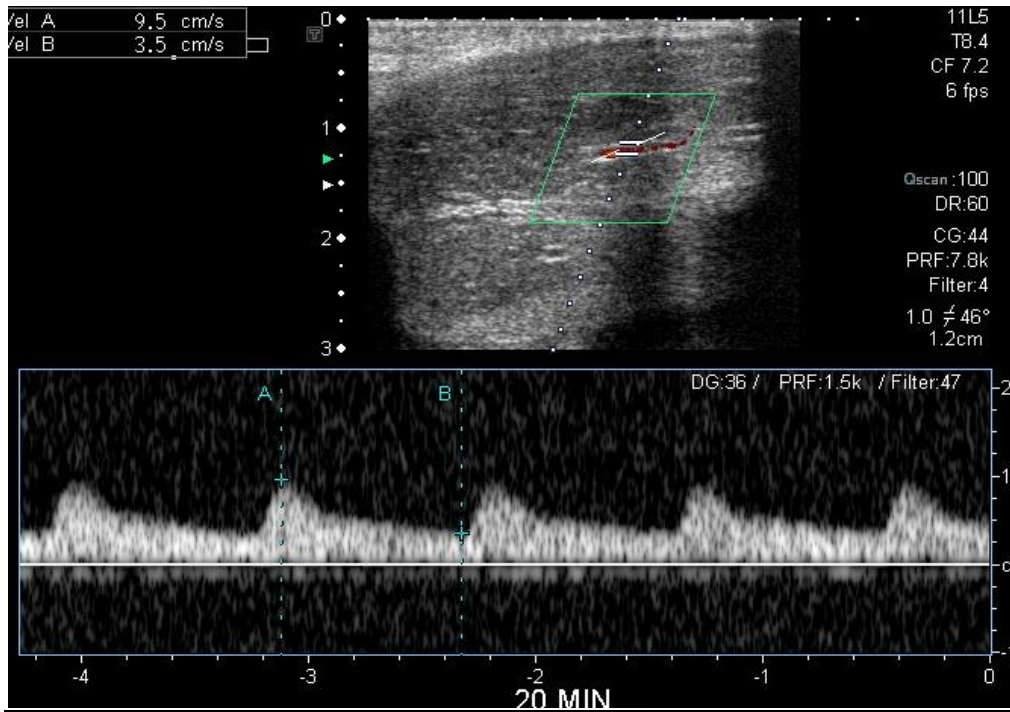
Color doppler at 20 minutes showing poor flow
